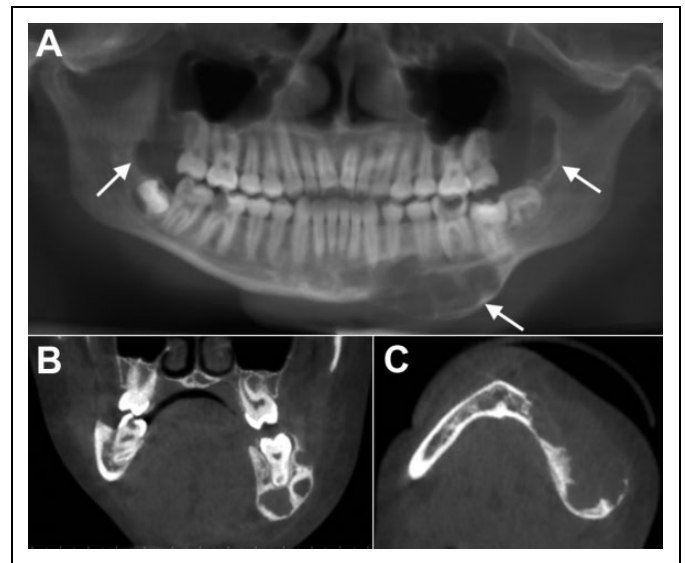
Multiple giant cell granulomas of the jaw in an otherwise healthy 14-year-old girl. A, Reformatted panoramic cone-beam computed tomography (CBCT) image shows 3 giant cell lesions throughout the mandible (arrows). B, Coronal CBCT image shows a multilocular lesion in the body of the left mandible. Note the thick, curved septa. C, Axial CBCT image demonstrate significant expansion of the mandibular body as well as destruction of the buccal cortex; also note the crenations causing scalloping of the endosteal surface.
